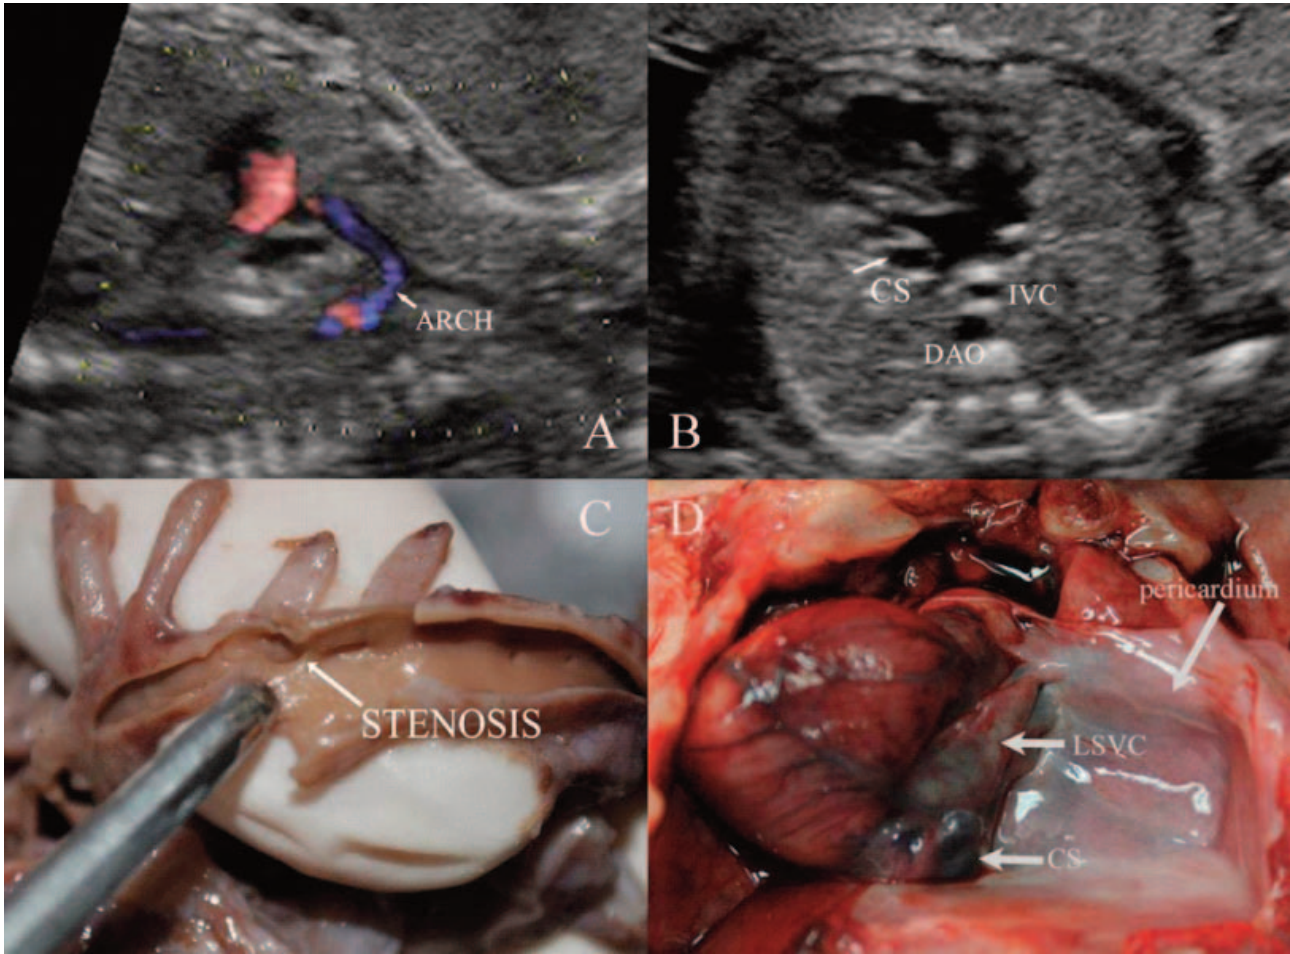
Comparison between the echocardiography diagnosis (coarctation of the aortic arch, permanent left superior vena cava, and coronary sinus dilation) at the gestational age of 25 weeks and the autopsy pathology after induction in the same fetus. A: The plane of the long axis of the aortic arch shows a thin diameter at the aortic arch (the coarctation of the aortic arch is indicated by the arrow), but color Doppler examination does not show noticeably abnormal blood flow signals; B: the four chamber plane shows a widened coronary sinus in the left atrioventricular groove; C: post-induction autopsy shows a ridge between the subclavian artery and the left common carotid artery at the aortic arch which leads to diameter narrowing (the narrowed site is indicated by the arrow); and D: post-induction autopsy shows a downward connection between the permanent left superior vena cava and the coronary venous sinus outside of the left atrium and ventricle. ARCH: the aortic arch; DAO: the descending aorta; IVC: the inferior vena cava; LSVC: permanent left superior vena cava; and CS: the coronary venous sinus.
